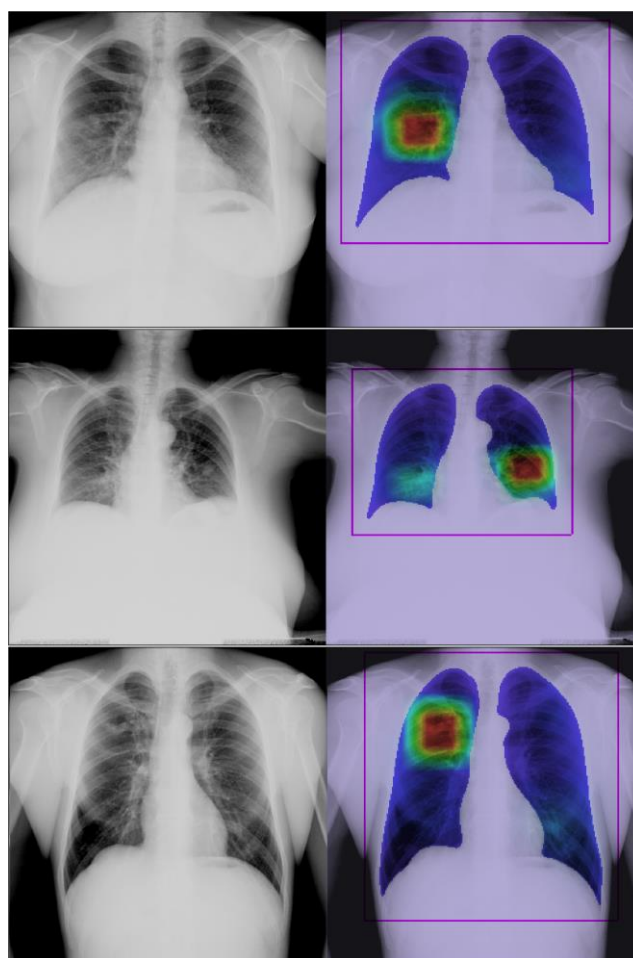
Examples of X-ray images and the corresponding AI processing results which have visual signs of abnormalities but were marked as normal in the screening database
